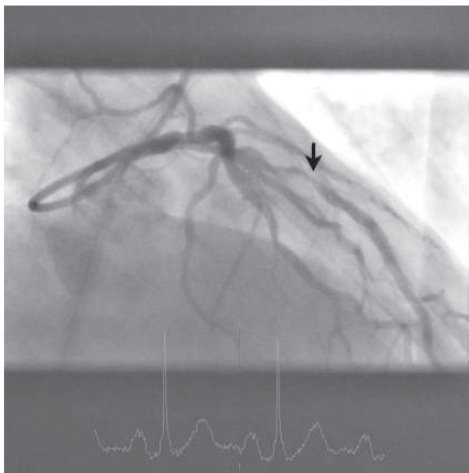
Example of a 76-year-old patient with PAOD. (a) Coronary CT angiography image. White arrow points to a mixed plaque in the proximal left anterior descending artery, with stenosis of the lumen. Calcium score was 553. (b) Short axis image of the adenosine perfusion MRI examination. White arrows point to a subendocardial perfusion defect in the septal wall, during stress. The perfusion defect was not present in the rest series, thus indicating inducible ischemia. (c) Invasive coronary angiography image of the left coronary arteries. Black arrow points to a significant stenosis, corresponding with the location seen on CT. (d) Invasive coronary angiography image after intervention. Good result after percutaneous coronary intervention with stent placement.
